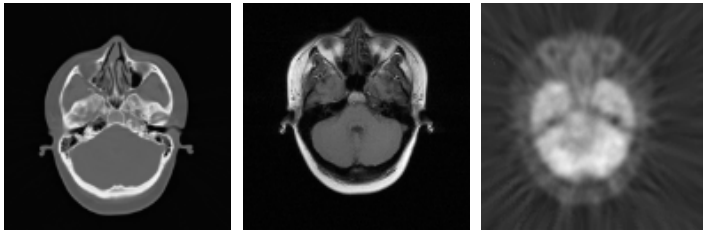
Axial slices of CT, MR (T1-weighted) and PET images from the patient 5 dataset
